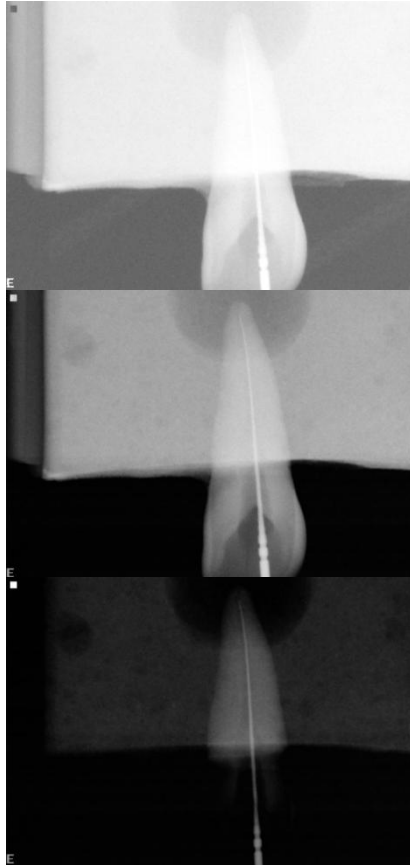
Under-, ideally and overexposed radiographs of a maxillary incisor.
